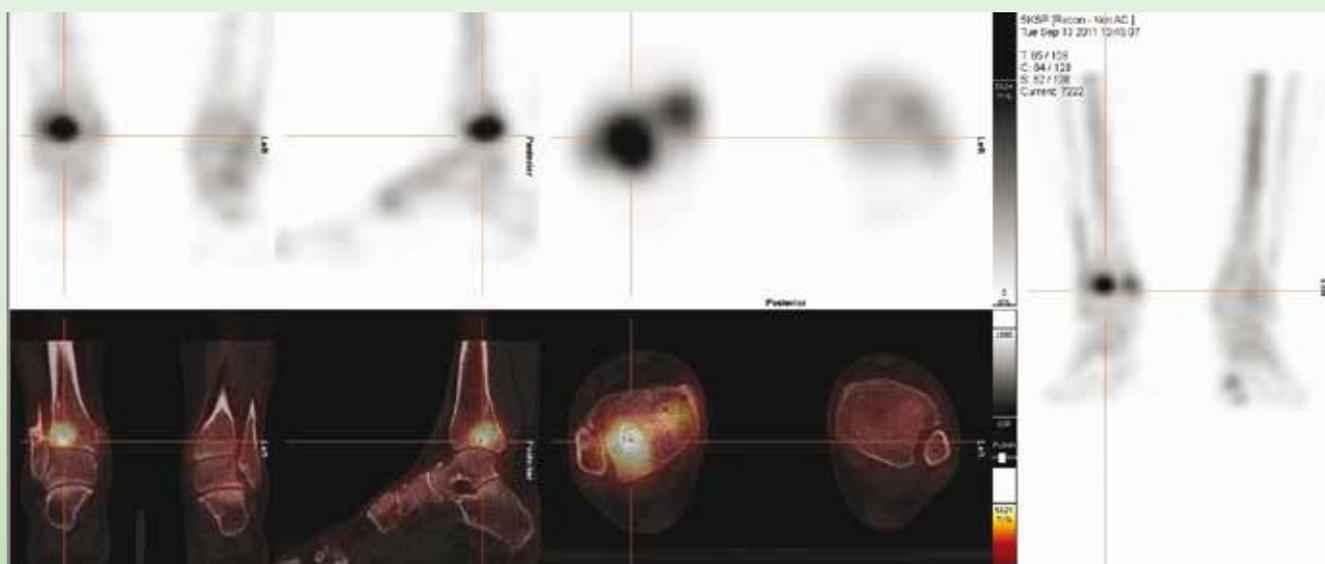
SPECT/CT of patient nr 4 showing increased uptake in the right distal tibia with subchondral bone cysts on low dose CT.
